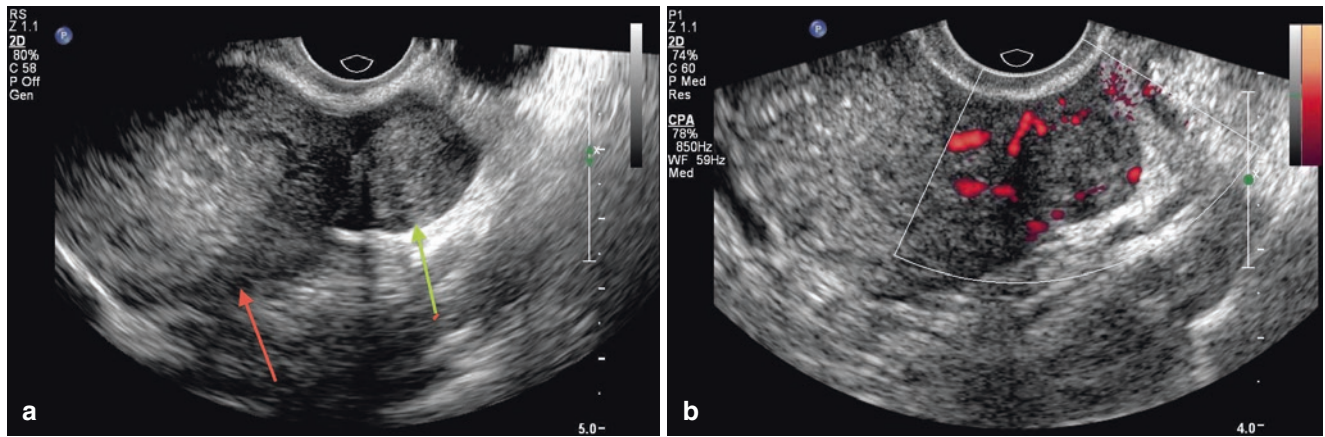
(a) Axial ultrasound section of the uterine body (*red arrow*), showing subserosal nodule in the left side wall that compresses the proximal portion of the left uterine tube (*green arrow*). (b) Power Doppler showing sparse vascularity within the myoma
